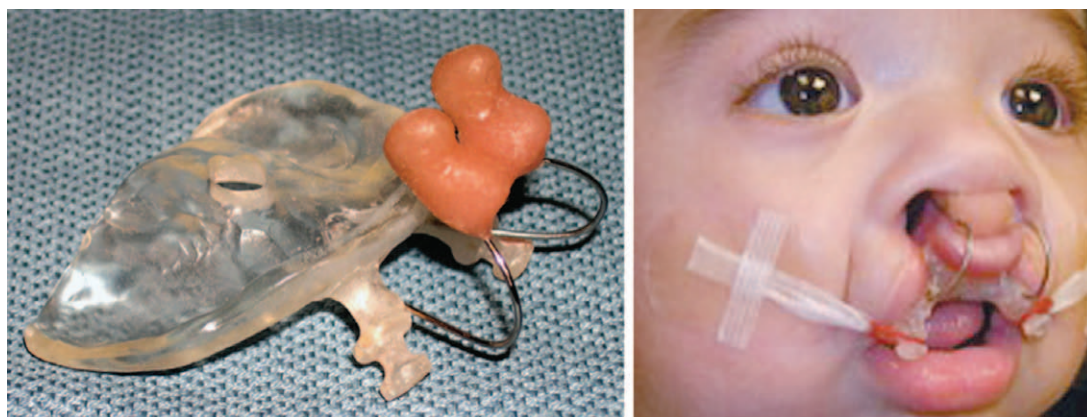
(Left) Nasoalveolar molding appliance for bilateral cleft showing nasal extensions attached to the palatal plate. (Right) Nasoalveolar molding appliance in place. (Reprinted from Lee CT, Garfinkle JS, Warren SM, Brecht LE, Cutting CB, Grayson BH. Nasoalveolar molding improves appearance of children with bilateral cleft lip-cleft palate. *Plast Reconstr Surg.* 2008;122:1131–1137.)
